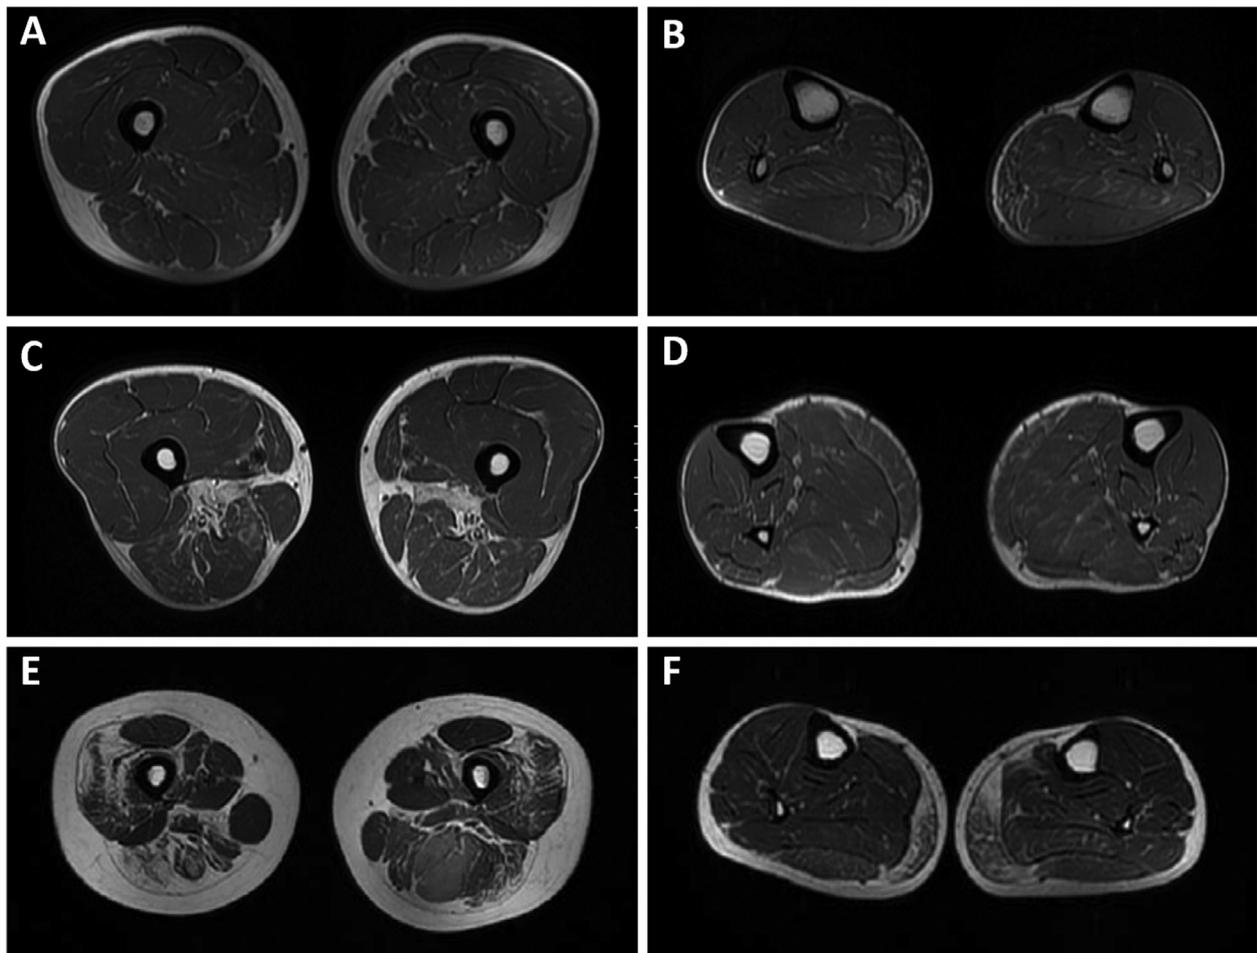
Muscle MRI in lower limbs revealed mild fatty infiltration in medial gastrocnemius in Patient 1 (A: thigh, B: Calf), and adductor longus involvement in Patient 3 (Fig. 3C-D). Fatty infiltration of vastus lateralis, vastus intermedius, adductor magnus and biceps femoris in thigh, and medial gastrocnemius in the calf was revealed in Patient 4 (Fig. 3E-F).
